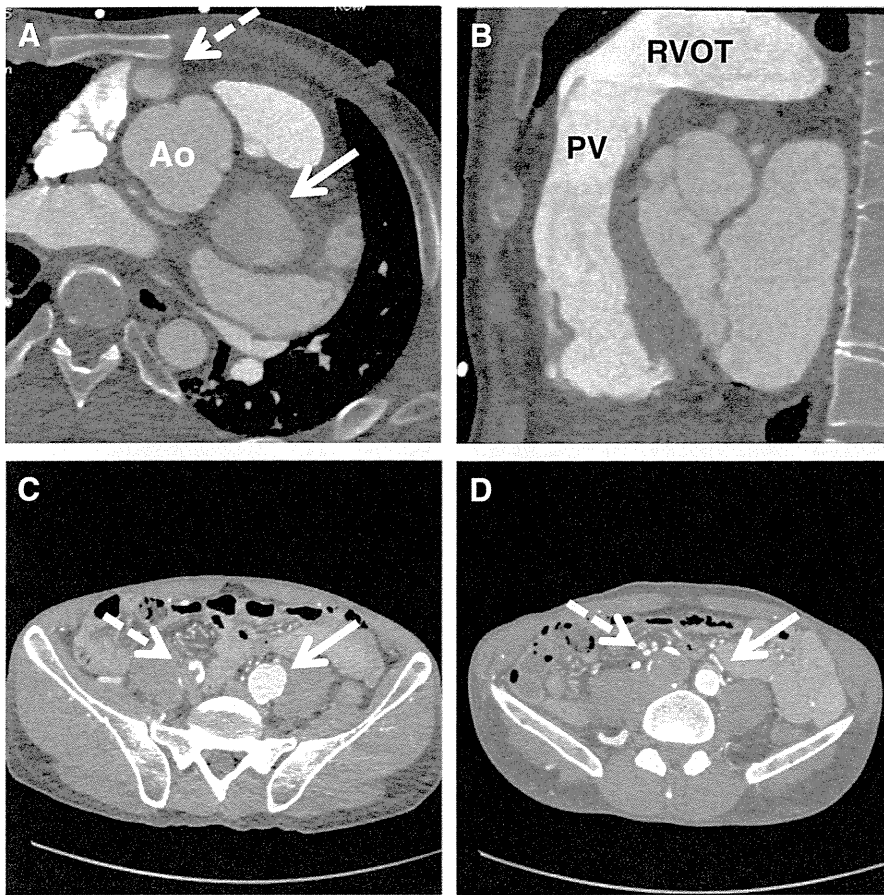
Computed tomography (CT) axial view showing aneurysms near left coronary artery (arrow) and the right coronary artery (broken arrow)(A). CT sagittal view with intact pulmonic valve (PV) and right ventricular outflow tract (RVOT). CT axial view at proximal (C) and distal (D) levels of common iliac artery showing occluded right common iliac artery (broken arrow) and dilated left common iliac artery (arrow).
